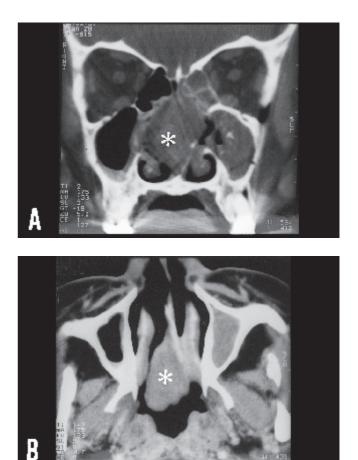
Contrast-enhanced paranasal sinus coronal (A) and axial (B) CT scans. A large soft-tissue density mass (*) is present in the right nasal cavity, right choanae and nasopharynx. The septum is deviated to the left side as result of a mass in the right nasal cavity. However, there is no evidence of bone destruction nor of extension of the lesion into the orbit or intracranial compartment.
